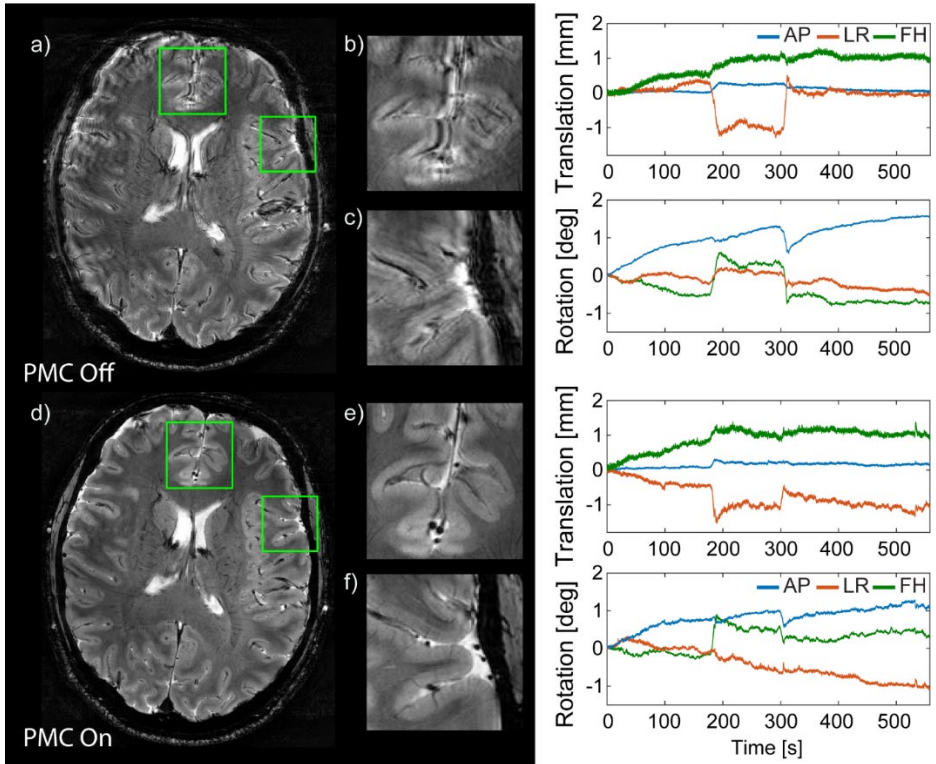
Left: T2-weighted imaging in vivo with subtle instructed head rotation about the FH axis. Significant motion artefacts (a-c) were virtually eliminated by PMC (d-f), resulting in image quality comparable to the PMC results without intentional motion. Right: corresponding rigid-body motion parameters.*
